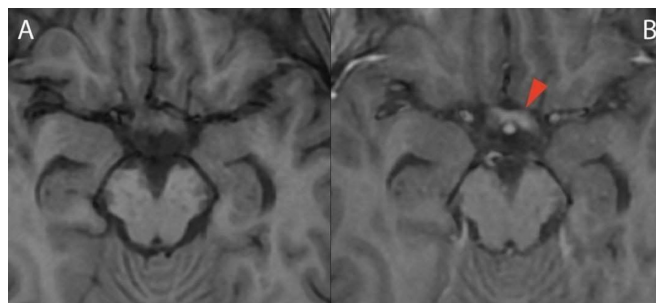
(A) Axial T1-weighted MRI of the head without contrast. (B) Axial T1-weighted contrast-enhanced MRI revealing patchy enhancement along the optic chiasm (red arrowhead).
